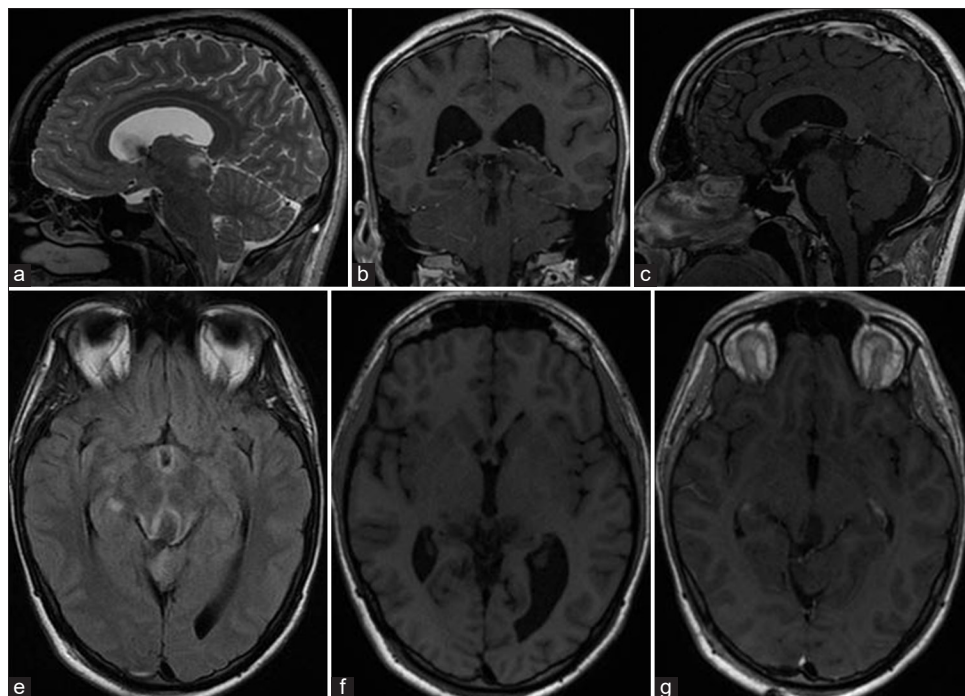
MRI scans (post operative) showing near total tumor removal (a, b, c, e and f). FLAIR (e) and T2W2 (a) show slight signal enhancement (small tumor remnant) in posterior part of thalamus and aqueduct.
